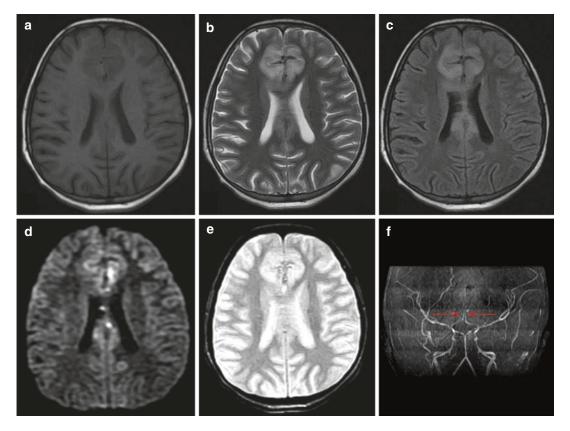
MRI of the brain depicts an infarction in a patient with TBM in the territory of anterior cerebral artery (ACA) (a–d) with no suggestion of hemorrhage (e, gradient recalled echo sequence). MRA is suggestive of involvement of both ACA (*arrows*, f)
